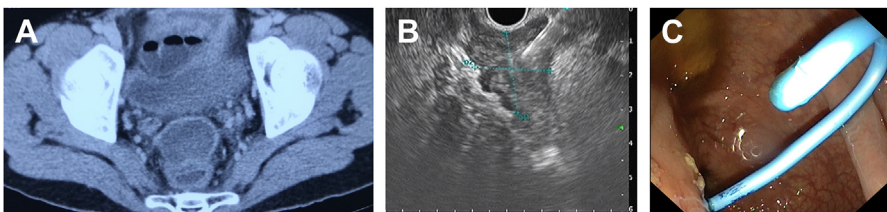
(A) Computed tomography pelvis revealing perianal abscess in a patient with Crohn's disease. (B) Endosonographic appearance of needle puncture of pelvic abscess. (C) Endoscopic ultrasound-guided abscess drainage using plastic stent.
